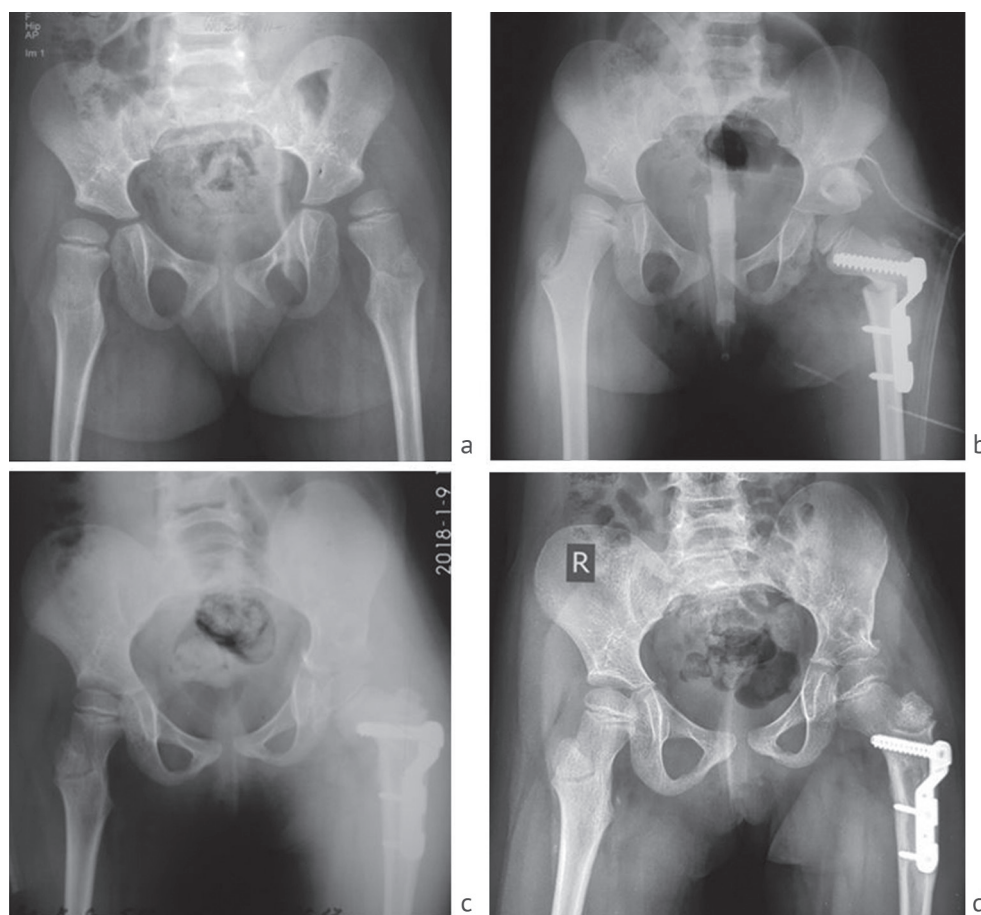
Improved parameters on the contralateral joint. Patient B., 7 years old, GMFCS level V. AP radiographs of the pelvis: a before surgery: Reimers index 34 % on the right and 73 % on the left; AI 26° on the right and 33° on the left; ADI 4.0 right, 5.2 left; b after surgery on the left hip: Reimers index 0 %; AI 17°; ADI 4.6; Wiberg angle 34°; c one year after the operation: Reimers index 18 % on the right, 0 % on the left; AI 30° on the right, 20° on the left; ADI 3.7 on the right, 4.0 on the left; Wiberg angle 32° on the right, 33° on the left; d 2 years after the operation: Reimers index 11 % on the right; 8 % on the left; AI 24° on the right, 23° on the left; ADI 4.2 on the right, 5.5 on the left; Wiberg angle 32° on the right, 26° on the left
